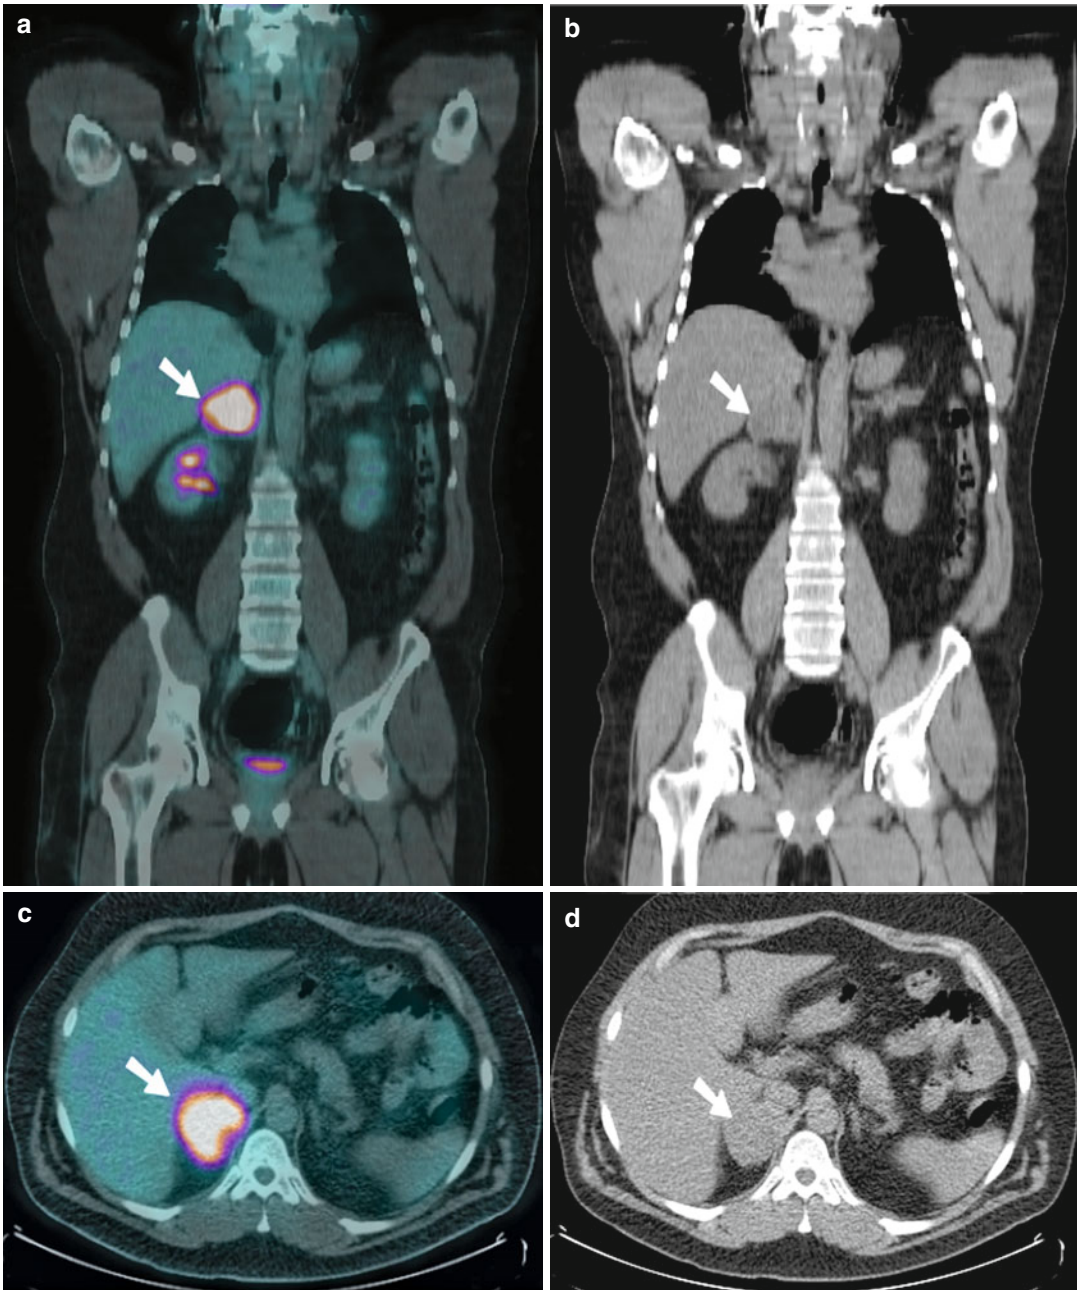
A 36-year-old man with newly diagnosed pheochromocytoma. (a, c) Fused PET-CT images and (b, d) CT images revealed intense focal FDG uptake within a right adrenal mass with a SUV_{max} of 17 (arrows). The patient also underwent a metaiodobenzylguanidine (MIBG) scan labelled with radioiodine (^{123}I) which
